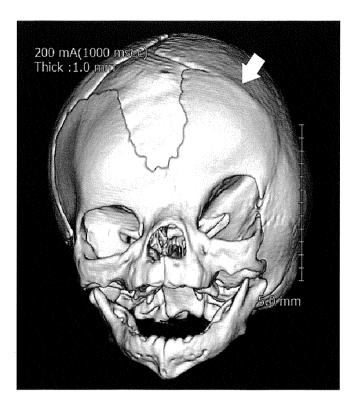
Three dimensional computed tomography image examined at 6 days after delivery. Craniosynostosis of the left coronal suture (arrow) is noted.
